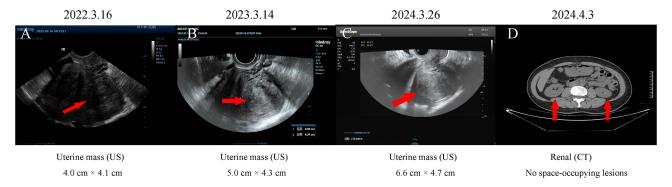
Figure I The timelines and follow-up imaging. (A-C) The ultrasound reveals a slightly hypoechoic mass in the posterior wall muscle layer, and the mass has been increasing in size annually. (D) Computed tomography indicates no significant space-occupying lesions in both kidneys.
